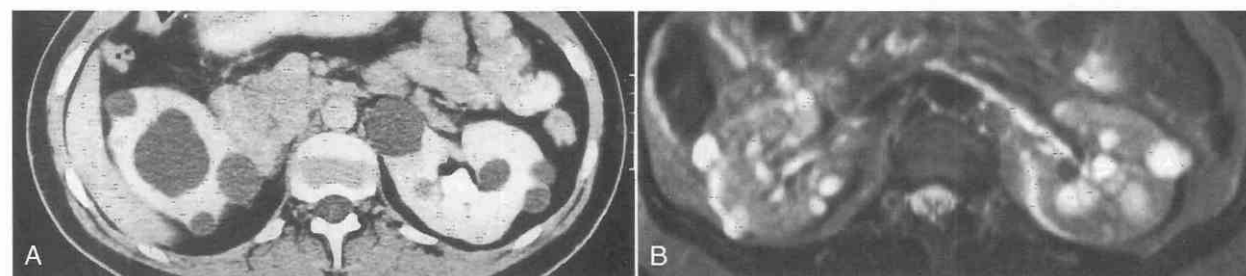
Multiple renal cysts in two different patients with von Hippel-Lindau disease. *A*, Contrast-enhanced CT scan shows multiple bilateral renal cysts. *B*, T2-weighted (TR = 2200 msec, TE = 90 msec) spin-echo MR image shows multiple cysts with high signal intensities involving both kidneys.
